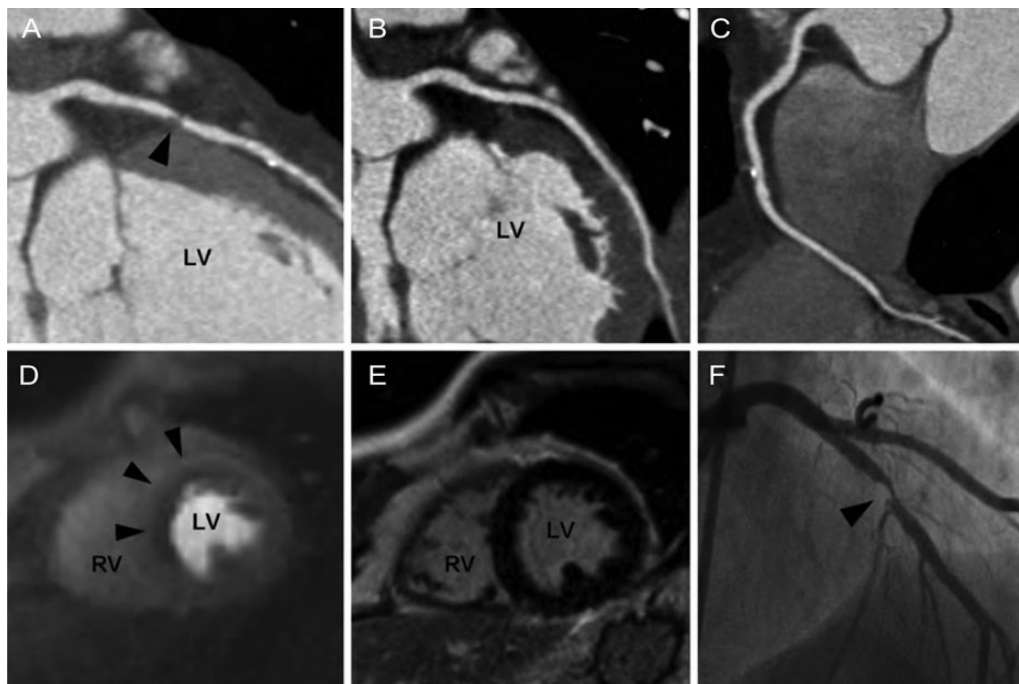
Case example. A patient with obstructive coronary artery disease on computed tomography coronary angiography in the left anterior descending coronary artery (A), normal circumflex coronary artery (B), and non-obstructive coronary artery disease in the right coronary artery (C). Cardiovascular magnetic resonance imaging showed an adenosine stress-induced perfusion defect in the anterior and anteroseptal myocardial wall (D, mid-ventricular short-axis orientation) and the absence of myocardial fibrosis on gadolinium late enhancement imaging (E). Invasive coronary angiography (F) confirmed significant coronary artery disease in left anterior descending coronary artery. LV, left ventricle; RV, right ventricle. From Groothuis et al.⁸
